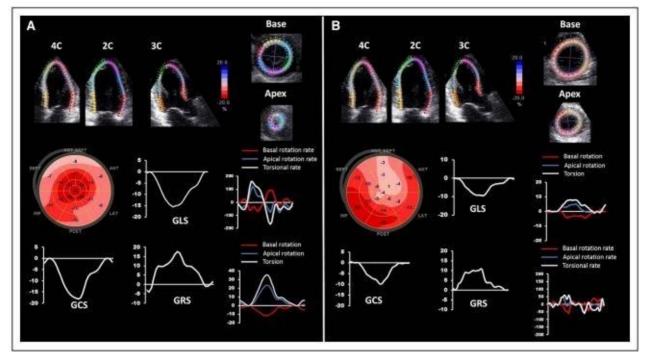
Speckle-tracking echocardiography-derived mechanics in patients with heart failure. A, An example of a patient with heart failure with preserved ejection fraction because of left ventricular hypertrophy caused by long-standing hypertension. GLS is blunted, whereas GCS and left ventricular torsion are exaggerated, thus, the preserved ejection fraction. Left ventricular untwist is delayed. B, An example of a patient with heart failure with reduced ejection fraction because of dilated cardiomyopathy. GLS is seen to be severely decreased compared with heart failure with preserved ejection fraction. In addition, mechanics in all other directions are also blunted, including reduced GCS, GRS, left ventricular torsion, and untwist rate, signifying the exhaustion of the compensatory mechanisms and the reduction of ejection fraction. 2 chamber; 3C, 3-chamber; 4C, 4 chamber; GCS, global circumferential strain; GLS, global longitudinal strain; and GRS, global radial strain.
